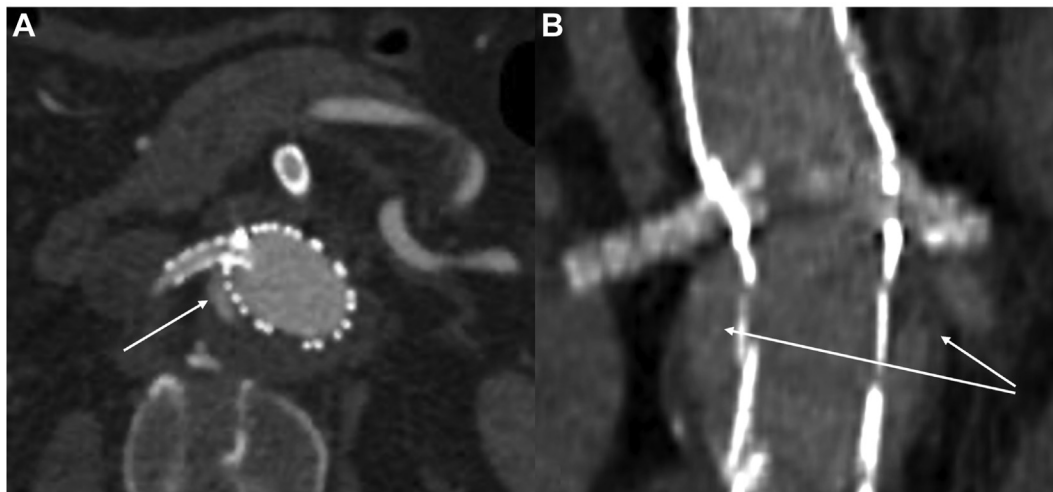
A, Computed tomography angiogram (CTA) axial view of a determinate target vessel endoleak (TVEL) (*white arrow*) arising from the interattachment site (type IIIc) at the level of the right renal fenestration. B, CTA coronal view of an indeterminate endoleak after fenestrated endovascular aneurysm repair (FEVAR) (*white arrows*), appearing as a contrast enhancement area at the level of fenestrations, without any clearly identifiable structural defect or source.
